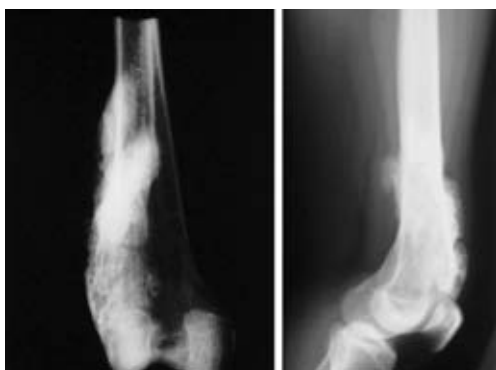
Frontal and lateral radiography of the parosteal osteosarcoma of right distal femur (case 2).
